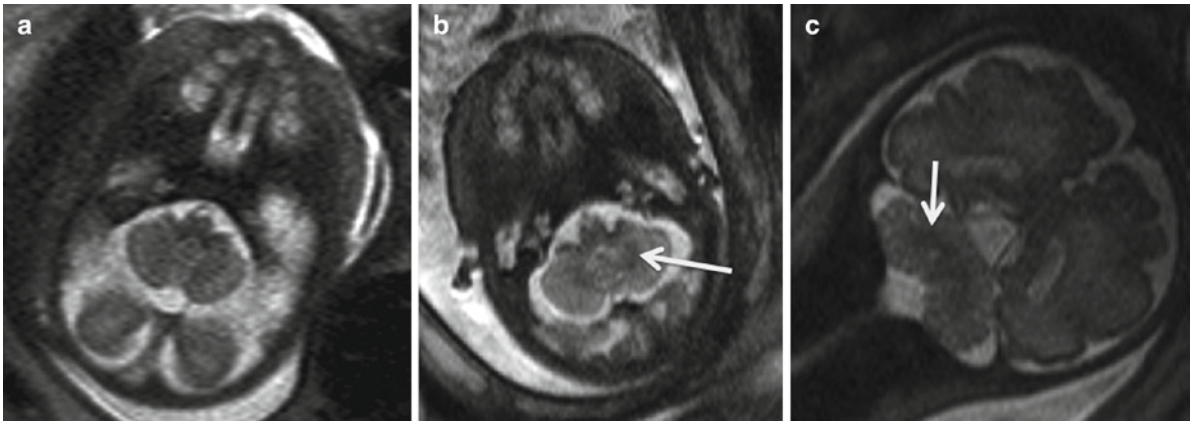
(a) Axial T2-weighted sequence of a fetus at 28 GW. The cerebellar hemispheres appear multilayered. Axial T2-weighted sequence (b) and coronal T2-weighted sequence
